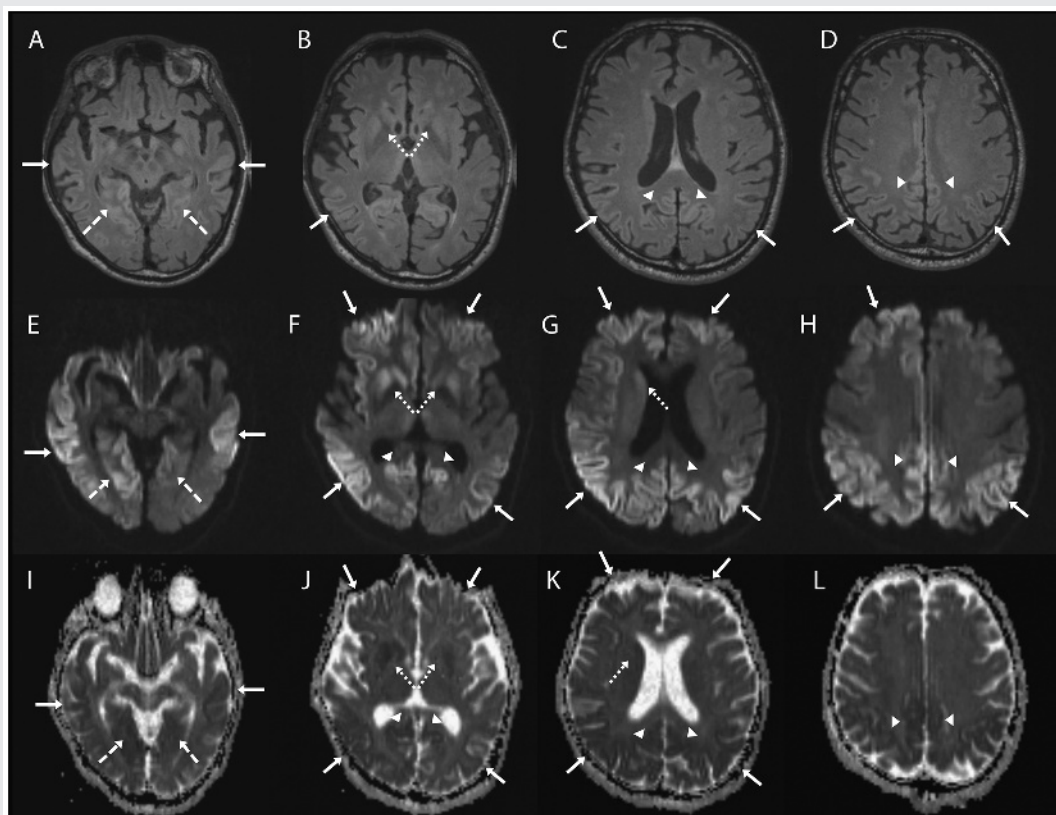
Axial brain MRI sequences in a patient with sporadic Jakob-Creutzfeldt disease. Note that the axial fluid-attenuated inversion recovery (FLAIR) sequences (A–D) are generally much less sensitive than the diffusion sequences, particularly diffusion-weighted imaging (DWI) (E–H) and the apparent diffusion coefficient (ADC) map (I–L). The DWI and ADC map show cortical ribboning (*solid arrows*) in the bilateral parietal, right greater than left frontal and lingula (*dashed arrows*), and posterior cingulate (*arrowheads*). Asymmetric involvement of the striatum is also shown (*right greater than left*) (*dotted arrows*). Bright regions on DWI are dark on the ADC map, indicating true restricted diffusion of water molecules. This case would meet University of California, San Francisco MRI criteria for sporadic Jakob-Creutzfeldt disease.¹⁶
